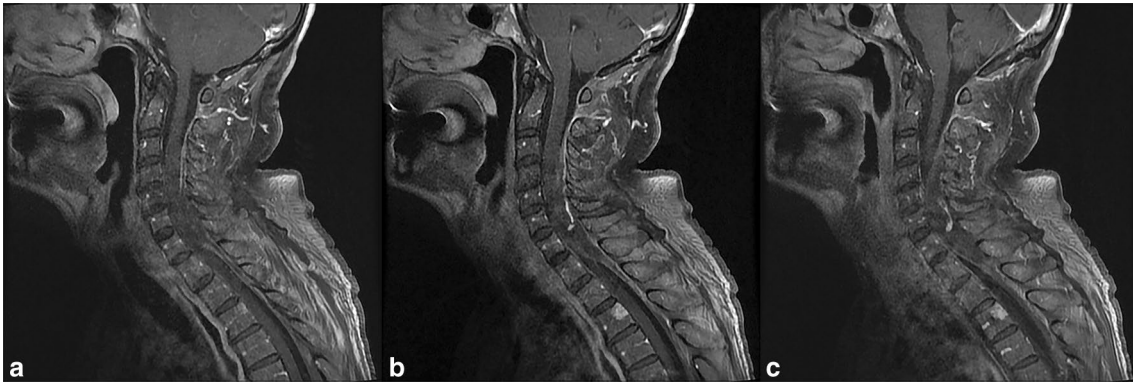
Pre-operative sagittal T1 weighted spinal MRI with gadolinium administration is showing an isointense mass lesion compressing the spinal cord between C4 and D1
